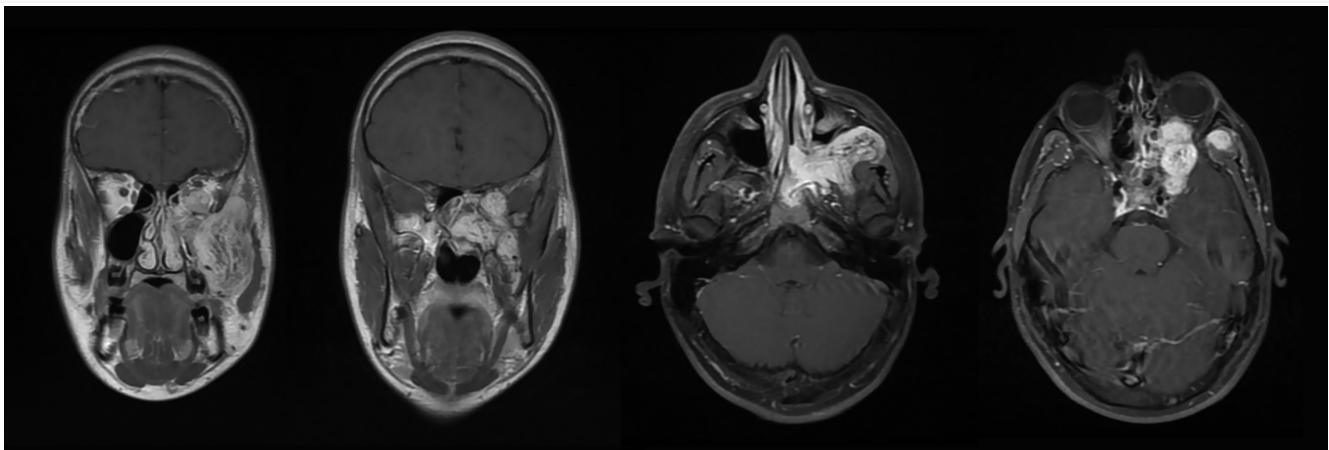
Preoperative magnetic resonance imaging (T1+contrast) of a patient with an advanced stage juvenile angiofibroma. Extension into infratemporal fossa, masticator space, inferior orbital fissure, orbit, and near the optic nerve.
